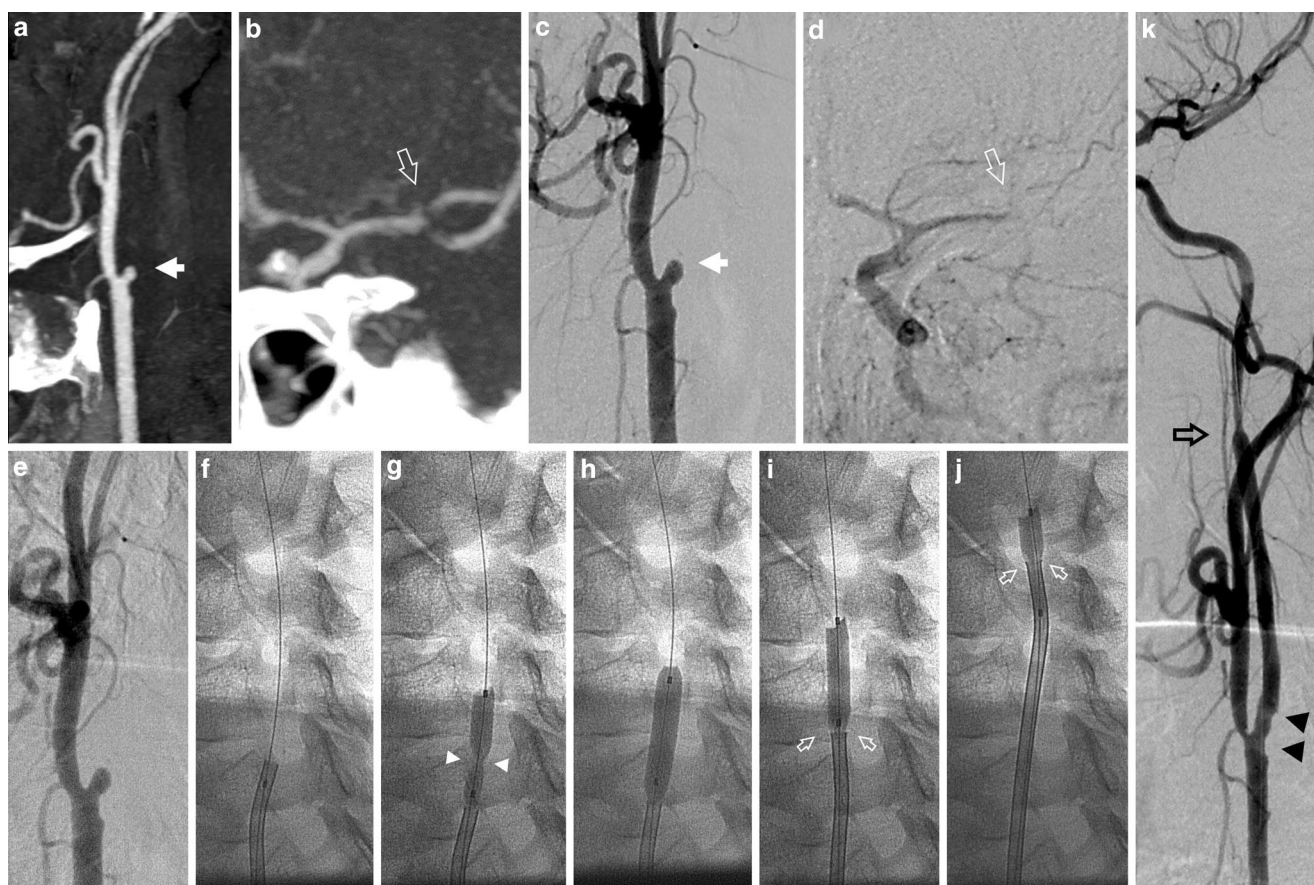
Demonstrative case of the balloon-assisted tracking technique showing the recanalization of a left-sided tandem ICA-MCA occlusion in a middle-aged patient with acute onset severe left hemispheric symptoms. a Preoperative CTA reveals proximal occlusion of the left ICA with a small, rounded stump (*white arrow*) and a filling defect in the left M1 bifurcation (b, *open white arrow*) with apparently good filling of the distal MCA branches. c Subtraction angiography confirms the ICA occlusion but shows a complete flow arrest at the M1 bifurcation (d, *open white arrow*). The field-of-view position on panels f, g demonstrating the BAT technique corresponds to that of panel e. f The procedure begins with the careful penetration of the ICA stump with a 0.014" microguidewire. The large lumen 8F soft tip guide catheter is then moved to the very end of the stump for sufficient back-up. g A low-profile coronary PTCA balloon with a diameter of 4 mm is positioned across the plaque followed by angioplasty by careful manual inflation of the balloon. The occlusion point (*white arrowheads*) is easily recognized. After complete inflation (h) the balloon is deflated passively (i.e., the syringe is detached from the conus) and the guide catheter is advanced over the balloon and then they are moved carefully together into the ICA (i, j). The partially deflated balloon forms a streamlined stylet (*white open arrows* on i and j), preventing the rim of the catheter to get in contact with the irregular surface of the plaque, precluding thereby shaving off plaque debris or plaque dissection. The balloon is deflated completely thereafter and is removed together with the microwire. The ICA lumen is then recanalized by careful manual aspiration through the guide catheter and the recanalization of the MCA is performed by ADAPT technique. k Selective injection of the left CCA at the end of the procedure shows the complete recanalization of the ICA and MCA. The *black open arrow* indicates the highest level to which the balloon-guide catheter complex was advanced. The recanalized plaque shows a smooth surface (*black arrowheads*), without signs of dissection, floating thrombus, or high-grade residual stenosis, therefore stent implantation was not pursued at the acute stage. The total time from the selective diagnostic run of the CCA to the complete recanalization (from panel c to panel k) was 8 min
